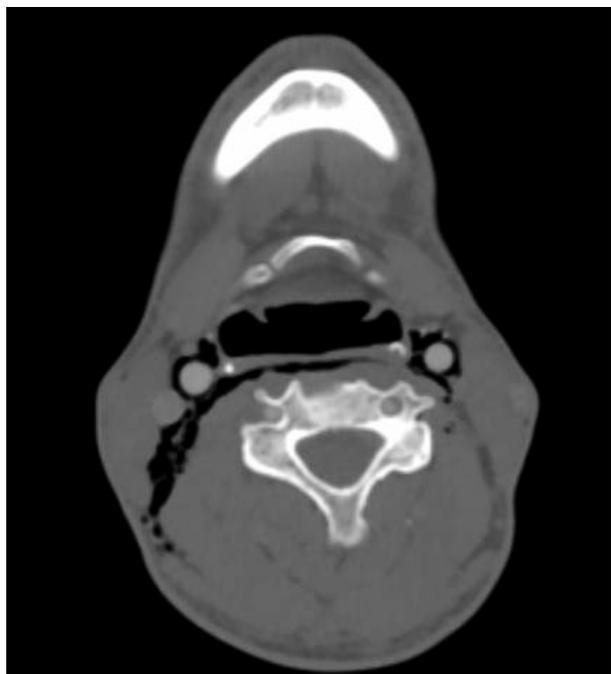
Axial computed tomogram showing bilateral subcutaneous emphysema extending to the retro- and parapharyngeal spaces.
